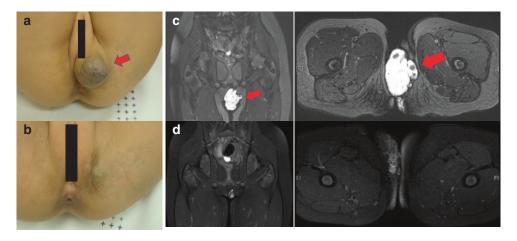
CC: mass on vulva. Dx: Venous malformation. (a) preop picture. (b) postop picture. (c) preop MRI. (d) postop MRI
